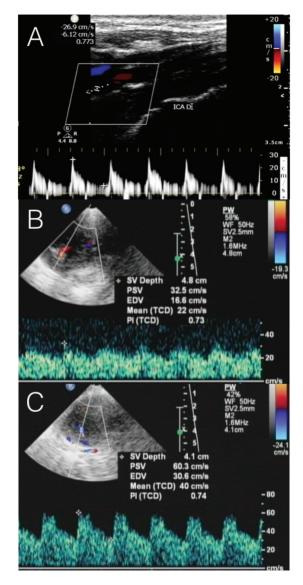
(A) Carotid duplex ultrasonography of the extracranial right internal carotid artery shows a higher resistance waveform pattern. (B) Transcranial color-coded duplex sonography (TCCS) of the right middle cerebral artery (MCA) showed a blunted waveform pattern. (C) TCCS of the left MCA showing a normal waveform pattern.
